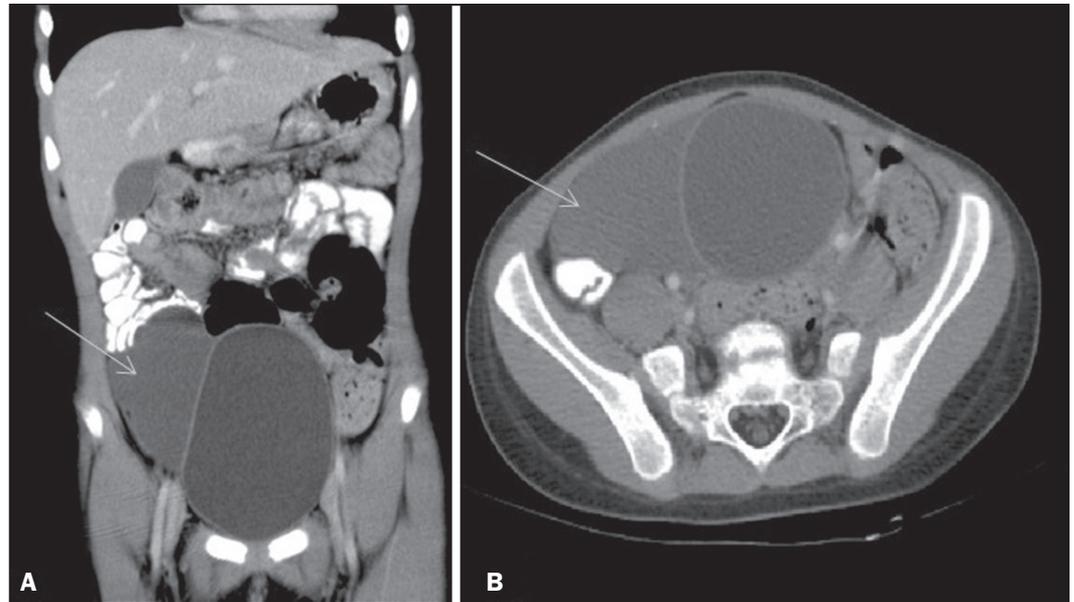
Coronal (A) and axial (B) reconstructions of contrast-enhanced computed tomography of the abdomen, showing a well-defined, hypointense collection with regular contours, with cystic attenuation, showing no enhancement and in contact with the right lateral wall of the bladder.
